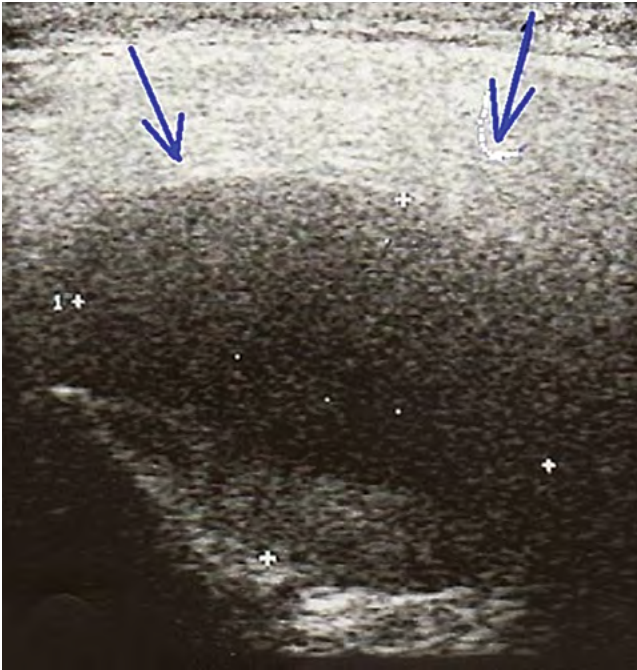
Ultrasound examination revealing the tumor (arrows).
